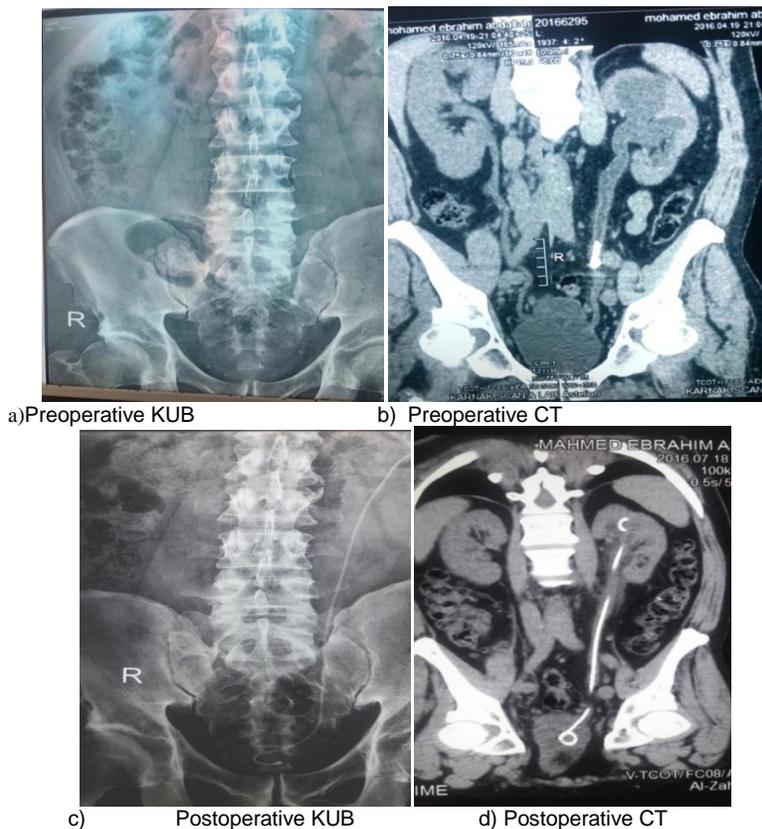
Male patient 50 years old, Ultrasound: left moderate hydroureteronephrosis. A) Plain KUB revealed stone left lower third ureter. B) Pelviabdominal CT: left hydroureteronephrosis and stone left lower third ureter. Procedure: ultrasonic lithotripsy with DJ insertion. Followup Postoperative. c) KUB: free Ultrasound: mild back pressure. d) CT: stone free.
